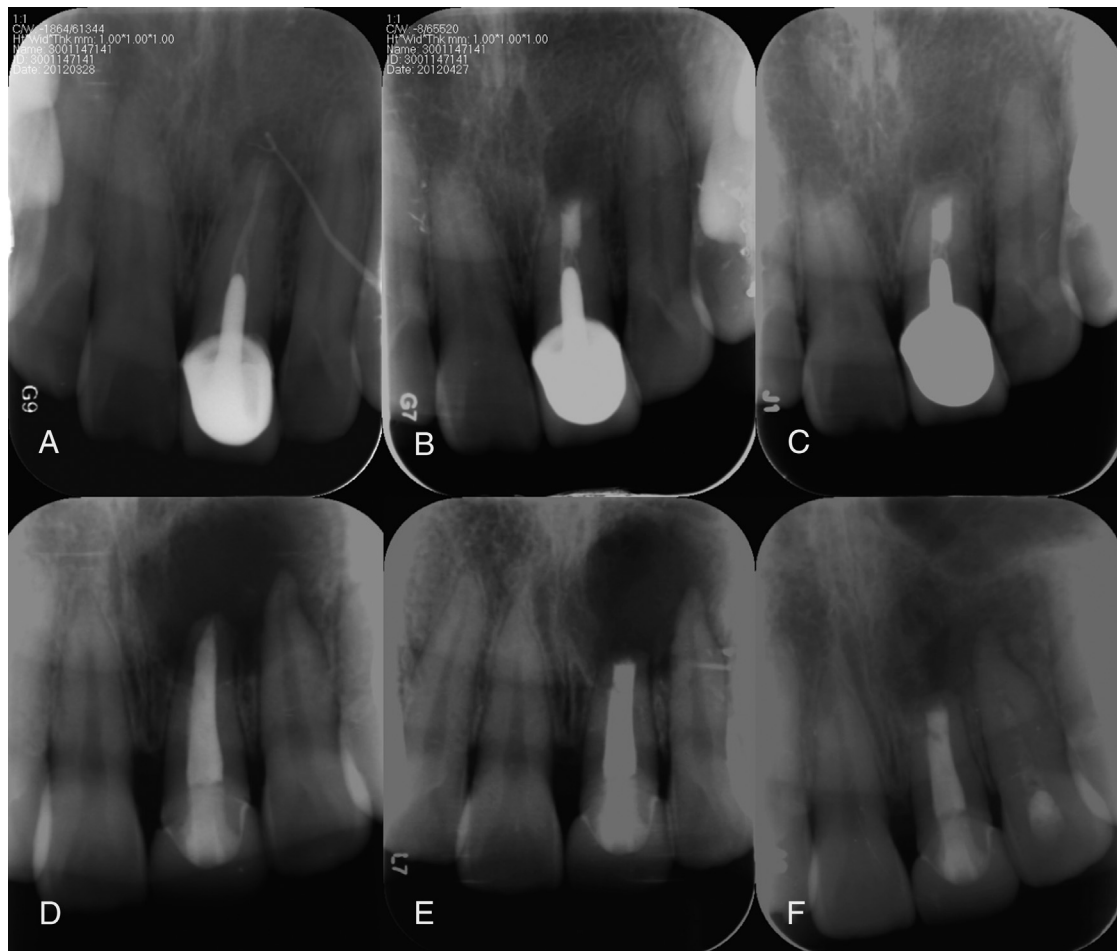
Examples of complete and incomplete healing. (A and D) The preoperative condition, (B and E) the immediate postoperative condition, and (C and F) the follow-up. (A–C) Reformation of the normal width and lamina dura around the apex (C) 20 months after the operation showed complete healing of the periapical lesion. (D and E) The 12-month postoperative radiograph showed that the radiolucency had decreased and the outline of the radiolucency was irregular in a case showing incomplete healing.
